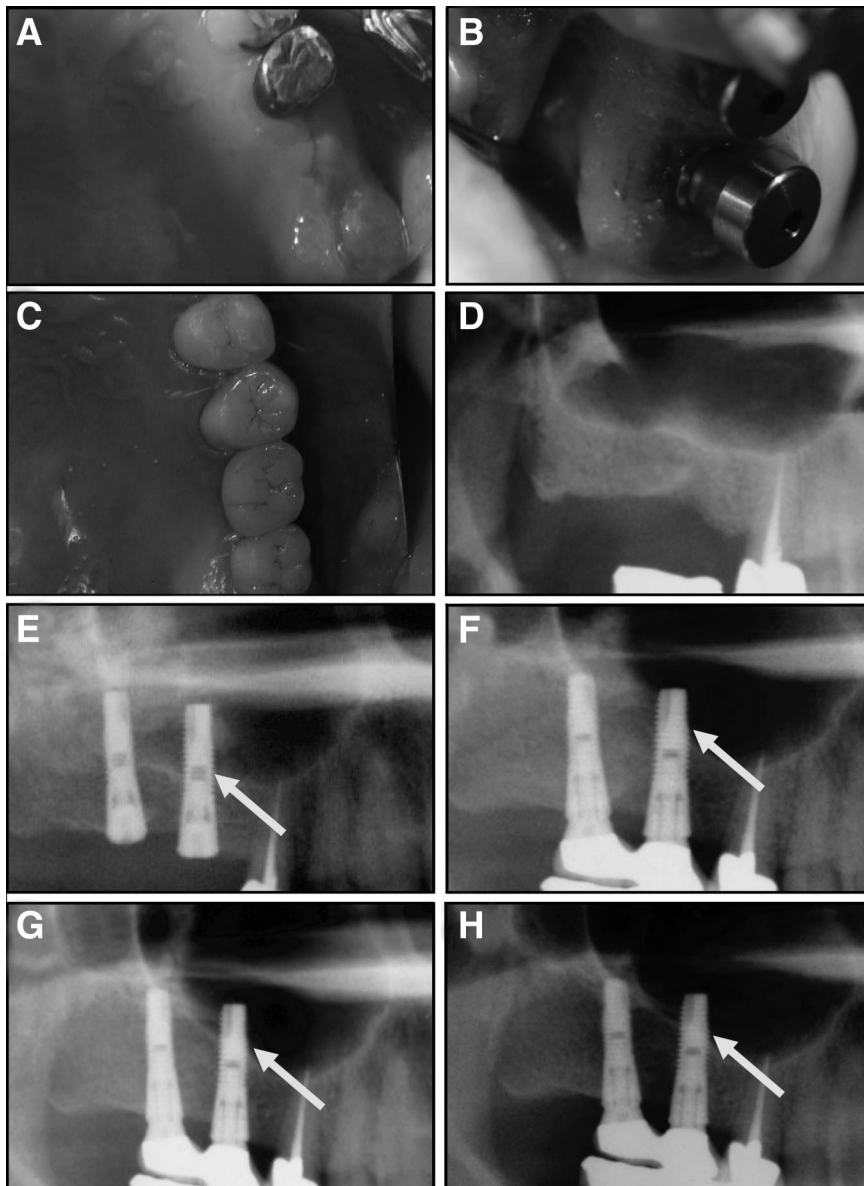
A, Preoperative macro view. B, Observation of second-stage surgery 6 months after the implant installation. The exposed thread was surrounded by newly formed bone and confirmed successful osseointegration. C, Last prosthesis observation by porcelain fused to a metal crown. These did not exceed 2 mm, and a healthy and firm peri-implant mucosa had been established. D, Panoramic radiograph of patient 3 in Table 1, preoperative. E, Panoramic radiograph of patient 3 in Table 1, postoperative. F, Panoramic radiograph of patient 3 in Table 1, postoperative 1 year. G, Panoramic radiograph of patient 3 in Table 1, postoperative 2 years. H, Panoramic radiograph of patient 3 in Table 1, postoperative 3 years.
